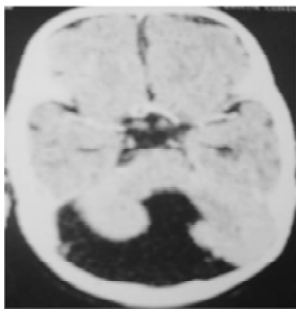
Plain CT brain showing Dandy Walker malformation
